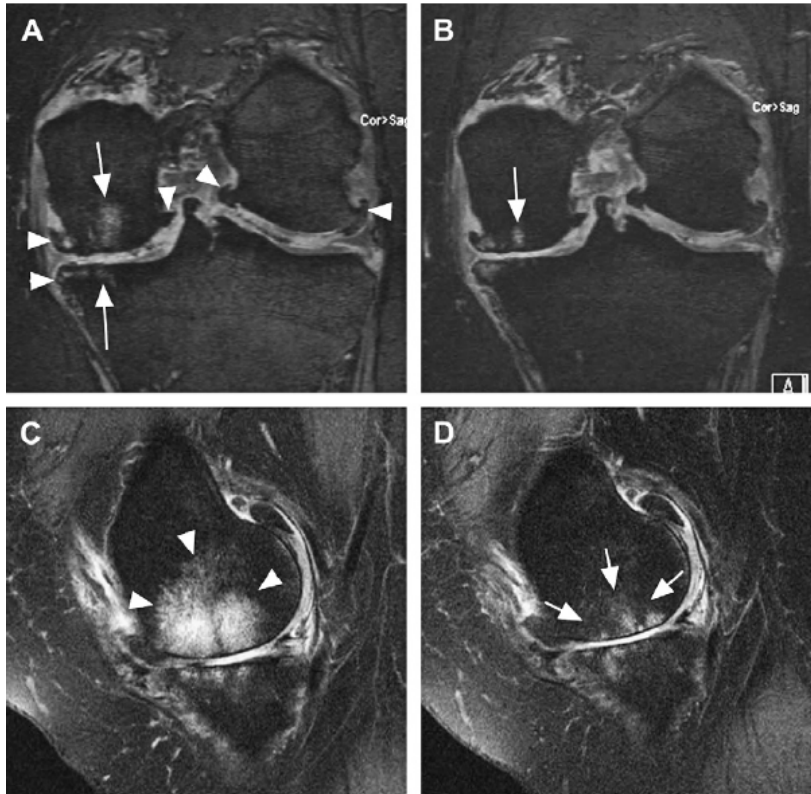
Longitudinal semiquantitative assessment of knee OA. (A) Baseline coronal double echo steady state (DESS) MR image shows central osteophytes scored for the medial and lateral compartments (arrowheads). Subchondral BMLs are shown (arrows). (B) MR image at 12 month follow-up shows increasing cartilage loss in the medial compartment but a decrease of the periarticular BMLs (arrow). The size of the osteophytes has not changed. (C) Sagittal proton density-weighted fat-suppressed MR image demonstrates a large BML in the central weight-bearing part of the medial femur (arrowheads). (D) MR image at 12 month follow-up shows a decrease in the size and signal intensity of the BML (arrows). Note that the BML is better depicted on the spin-echo images (C, D) than on the gradient-echo images (A, B).
